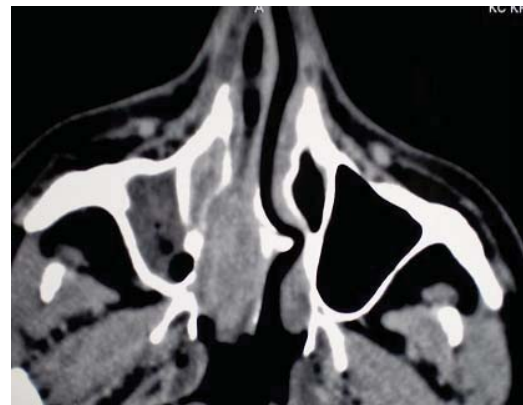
Computed tomography of paranasal sinuses (axial view) shows a heterogenous soft tissue mass in the right nasal cavity which arised from the last third of the nasal septum and obstructing the choana
